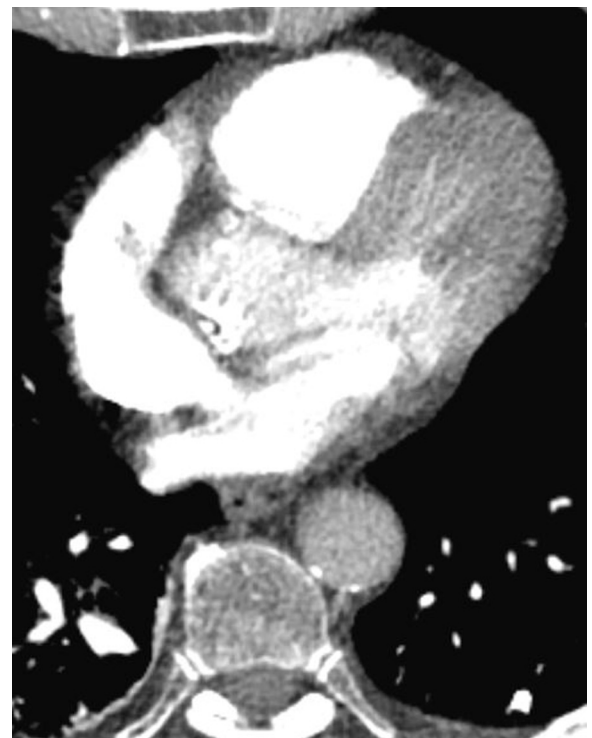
Right ventricular dilation on CT. (Original: 103 × 161329 mm [120 × 120 DPI].)
